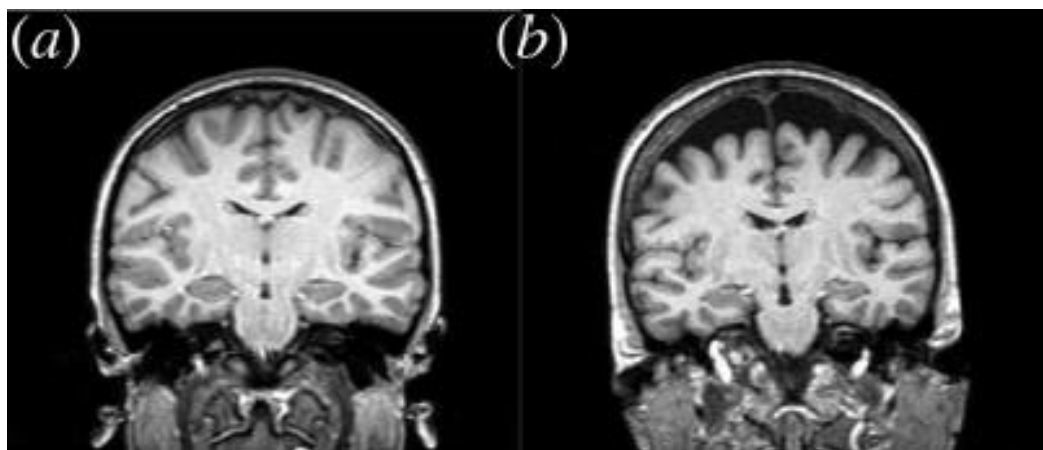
Human brain MRI of (a) young and (b) aged. Cerebral atrophy can be seen in the aged human.
